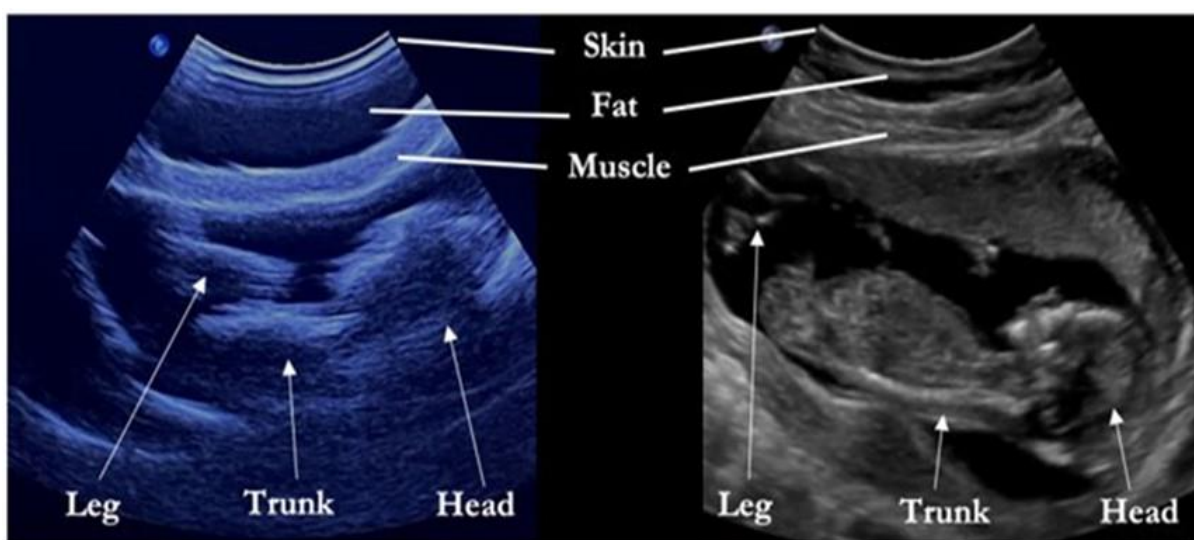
Sonographic of model (left) to live patient (right).
